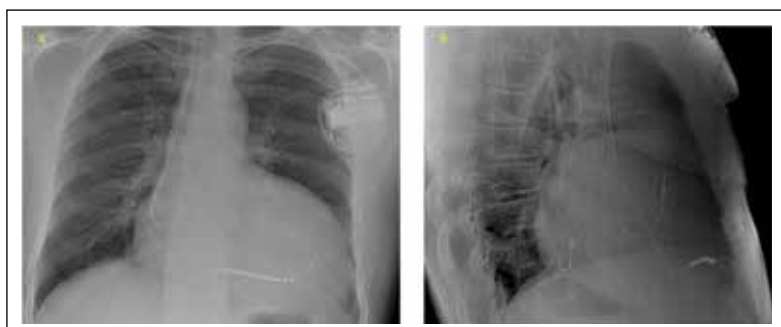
Frontal and lateral chest radiographs of a patient with a Medtronic CRT-D device. Note the ICD lead was inserted in the typical location of the apical septum. There is a good spatial separation between the LV and RV leads, which favours the CRT response.
